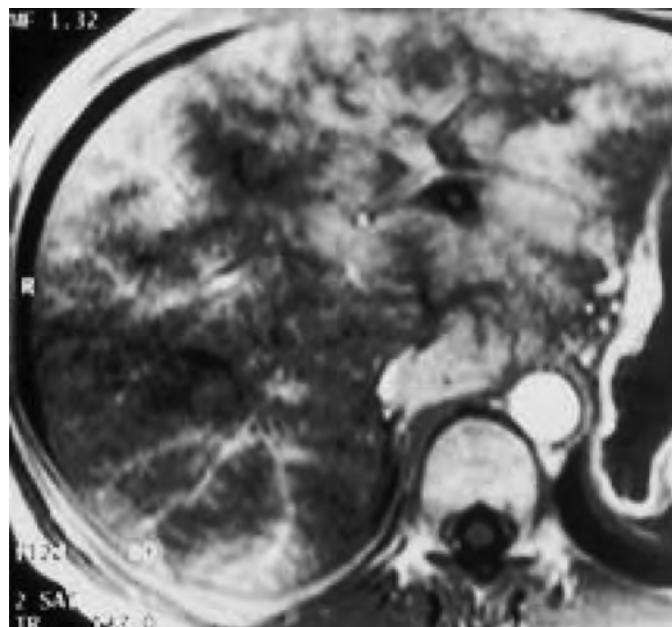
Acute Budd-Chiari syndrome: MR findings. The liver is edematous and inhomogeneous in signal intensity on this MR image.
